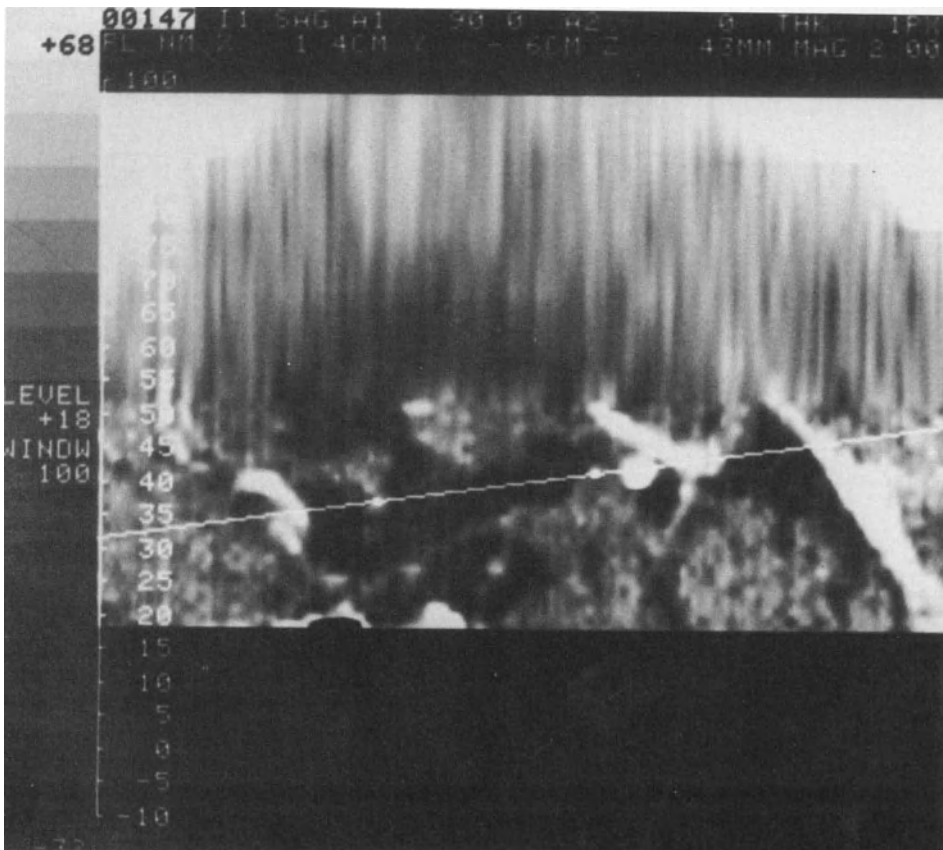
Reformatted sagittal CT image. A line runs through the anterior and posterior commissures.
